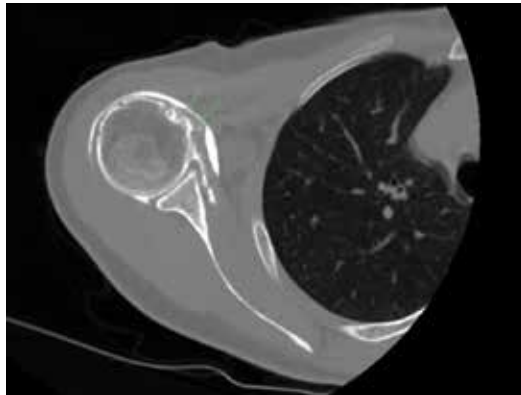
Axial view of computed tomography arthrogram showing the LHBT in the groove.
